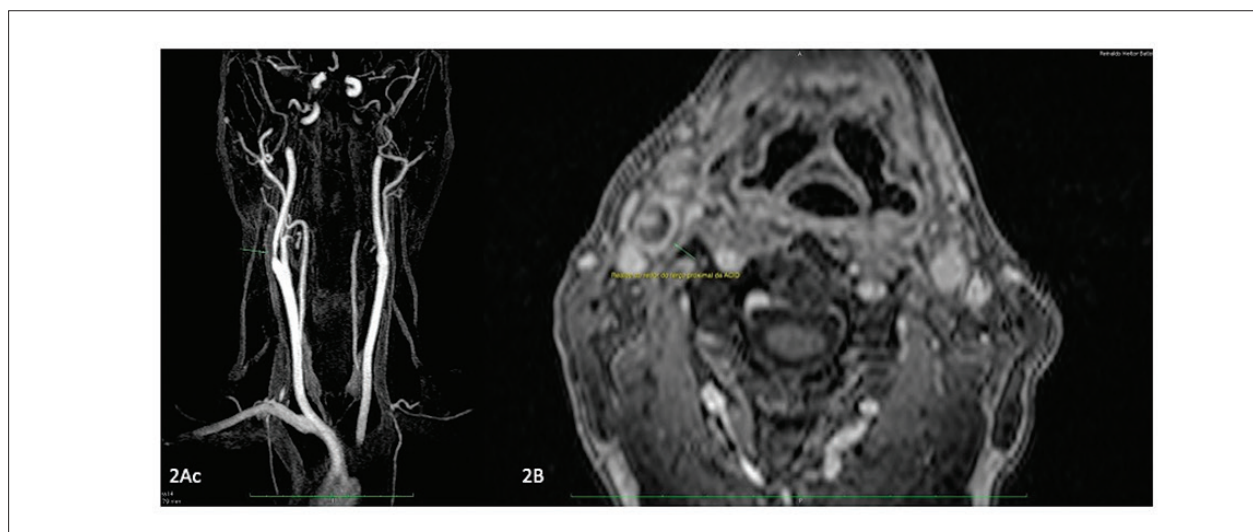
MRI and magnetic resonance angiography (MRA). A) MRA showing a 70% reduction in the lumen of the proximal ICA; B) Irregular thickening with contrast enhancement in the periphery of the ICA. Cortesy: Fernando Santos Emerick Gomes M.D. Federal University of Espírito Santo.
